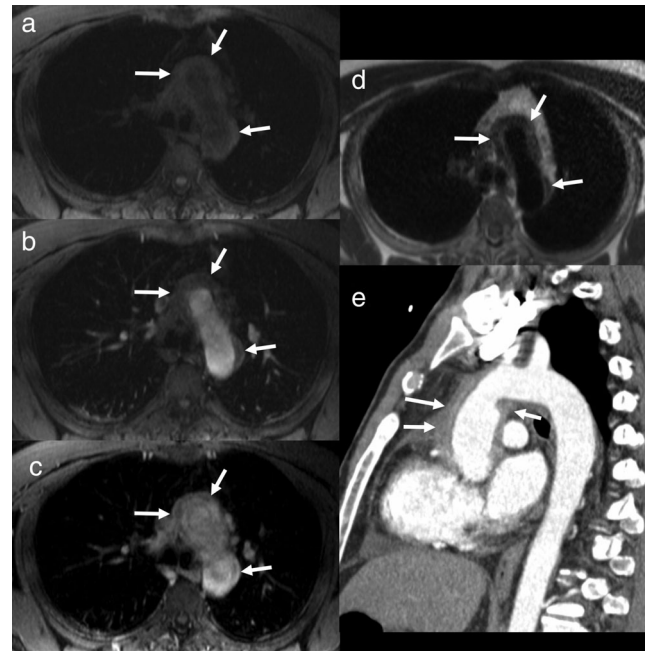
Volume-interpolated GRE and delayed imaging of periaortitis in a 42-year-old man presenting with chest pain. Precontrast volume-interpolated GRE (a), postcontrast volume-interpolated GRE after a 90-second delay (b), and postcontrast volume-interpolated GRE obtained after a 5-minute delay (c) show a circumferential rind of soft tissue surrounding the aortic arch (arrows), which demonstrates progressive contrast enhancement most pronounced after a 5-minute delay. Corresponding transaxial T₂-weighted black-blood single-shot FSE MR image (d) show intermediate signal intensity soft tissue surrounding the aorta (arrows) rather than within the aortic wall, suggestive of periaortitis rather than vasculitis. Contemporaneous oblique coronal CT image (e) demonstrates the extent of periaortic involvement (arrows), which included the ascending aorta and aortic arch. Immunologic workup was positive only for elevated inflammatory markers, and the patient was initiated on mycophenolate mofetil.
